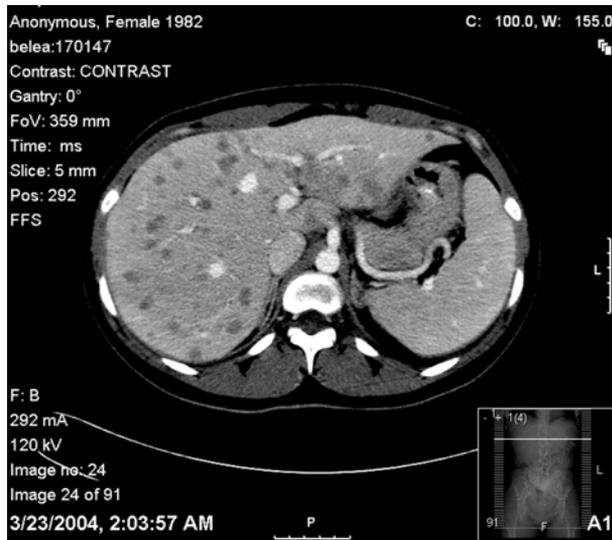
Numerous low-density lesions involving the liver on CT scan
